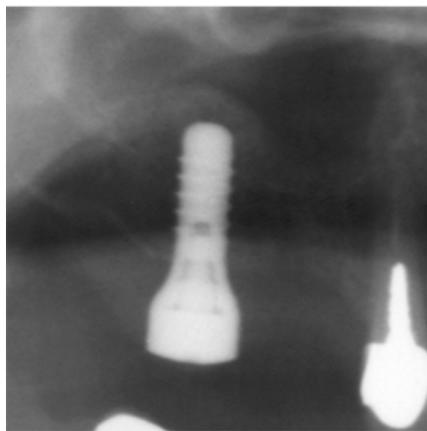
An orthopantomograph with the inserted implant. The bone augmentation mixture of Bio-Oss[®] and autogenous bone is clearly visible as a hemispherical shadowing. Nearly 100 mm³ of autogenous bone and 100 mm³ of Bio-Oss[®] are used and the osteotome penetrates into the sinus space to a depth of 2 mm. Eight osteotome pumping insertions were made, and the graft is low X-ray-contrasted. Each pumping conveys nearly 200 mm³ graft, but the largest part of it is blood. The larger volume of the domed elevation indicates clearly the hydraulic rise of the membrane.
